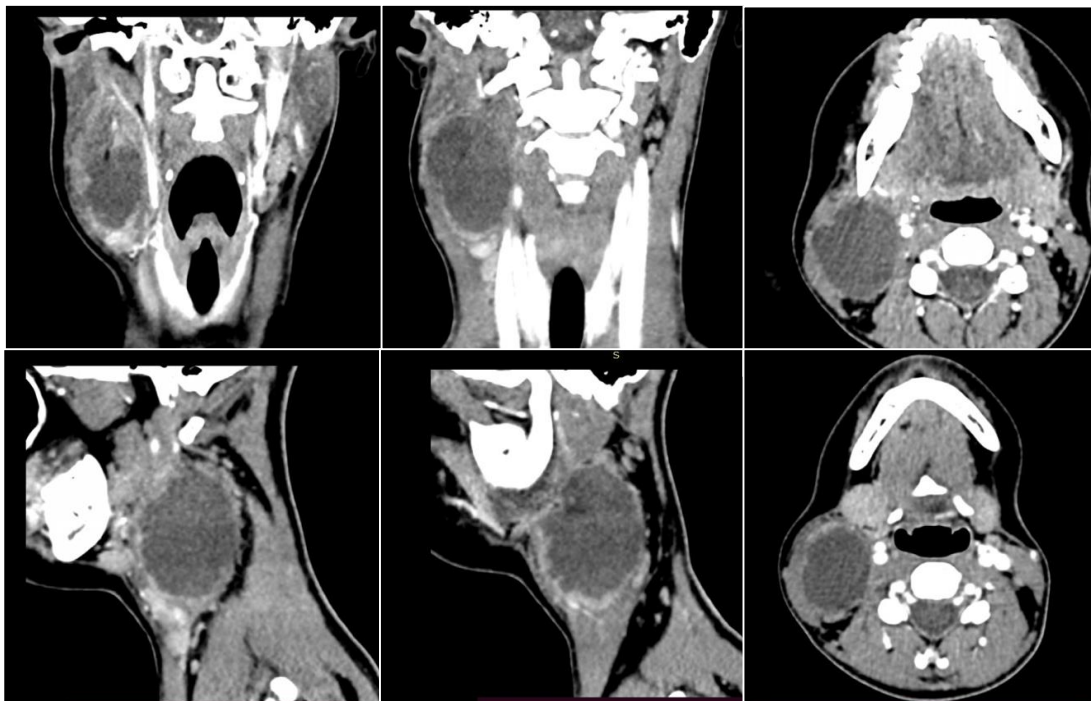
Patient R.E., 14 years old. Preoperative CT: imaging data suggestive of a cystic formation of the soft tissues of the neck, possibly an infected type 2 gill cyst (explanations in the text).
